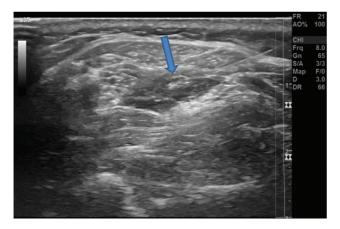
(Case 1)—Ultrasonography image post-drug injection into the perineural sheath.
